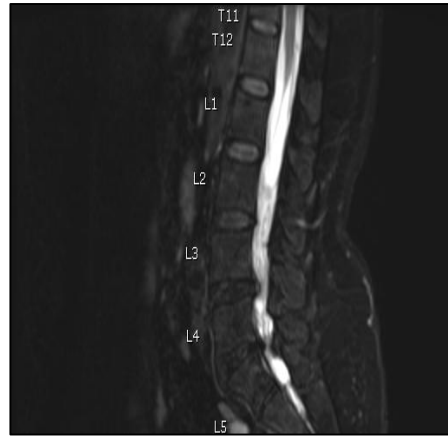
Degenerative Discal Changes with Disc Bulges in a 70-Year-Old Female. Sagittal T2 FAT SAT MRI Image of the Lumbar Spine Demonstrates Disc Desiccation Consistent with Modified Pfirrmann Grade 5. Associated Posterior Disc Bulges are noted at the L3/L4 and L4/L5 Levels
